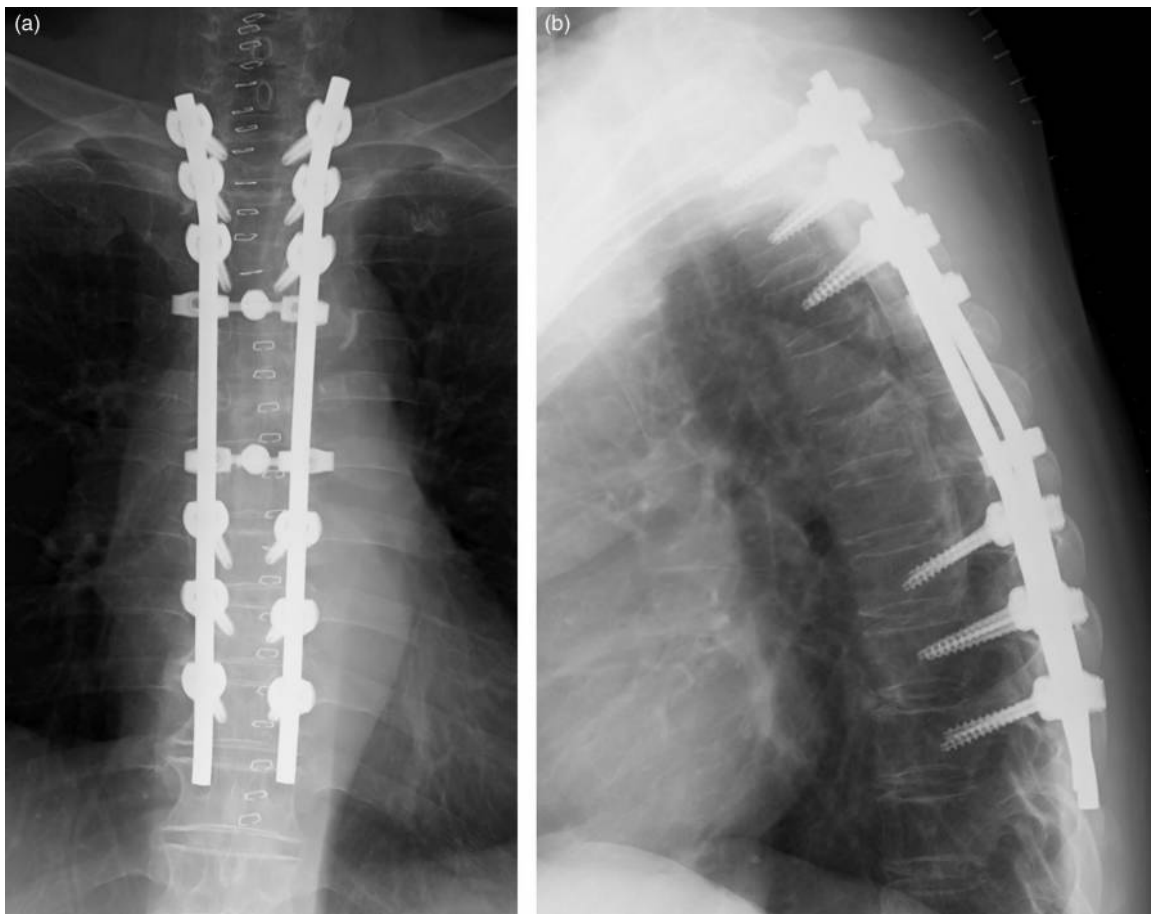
A AP view, plain radiograph of the thoracic spine, immediately after surgery. Posterior decompression and fusion (laminectomy for T3 to T7 and pedicle screw fixation and posterolateral fusion for T1 to T9) were performed. B Lateral view, plain radiograph of the thoracic spine, immediately after surgery.
